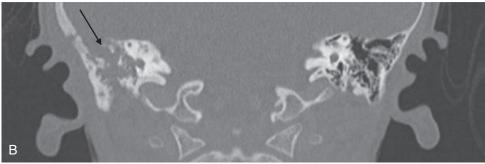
Axial (A) and coronal (B) CT scans of a patient with Langerhans cell histiocytosis of the right temporal bone. A, Opacification of the mastoid with loss of bony septations and erosion of the bone separating the cranial fossa from the mastoid cavity (arrow). B, Bony erosion caused by the tumor and the erosion of the mastoid tegmen (arrow).
